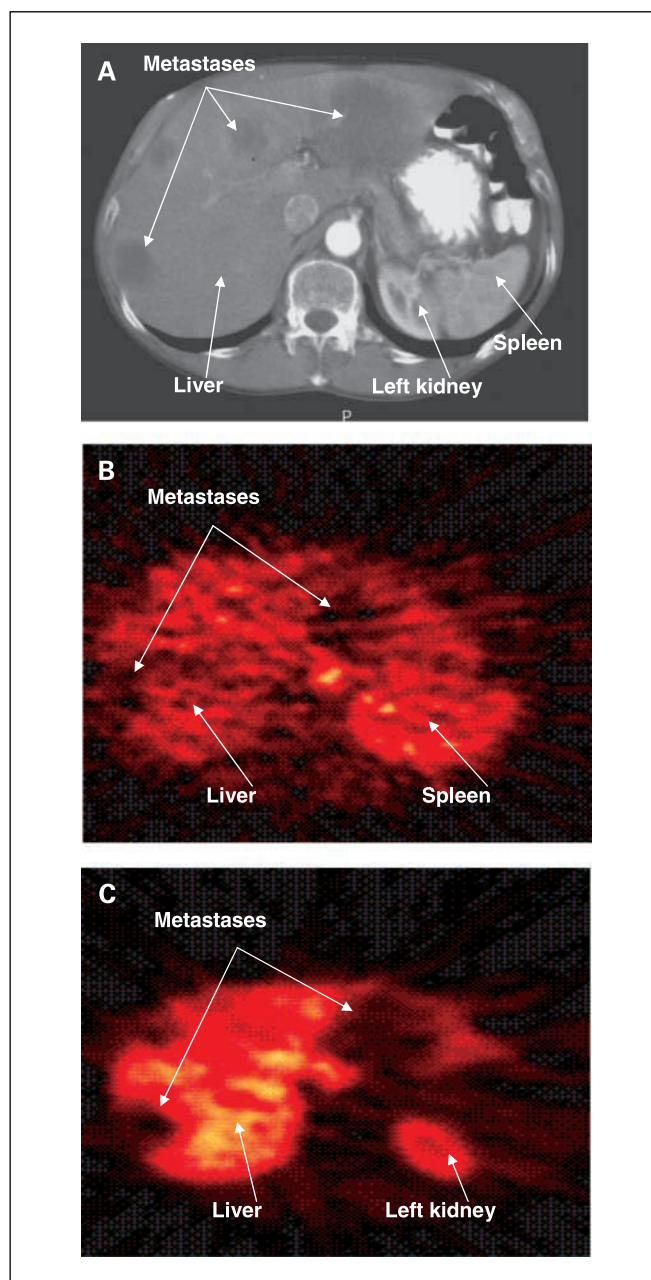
Typical transabdominal computed tomography (A), [^{15}O]H₂O (B), and [^{18}F]5-FU (C) images for a patient with metastatic colorectal cancer. Arrows, analyzed tissues.
